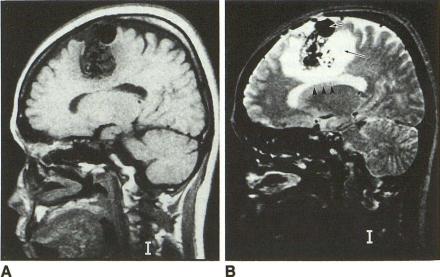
A, Sagittal T1-weighted (400/25) MR image demonstrating the convoluted vascular signal voids of an arteriovenous malformation.
